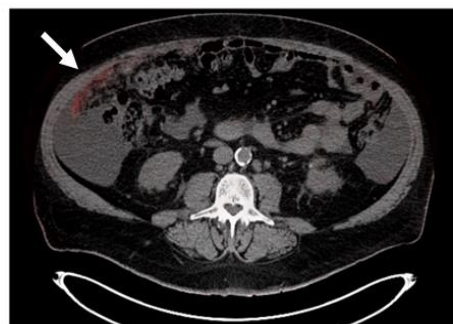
PET/CT scan with radiopharmaceutical deposit in the peritoneal cavity especially, pre-hepatic space (arrow)
